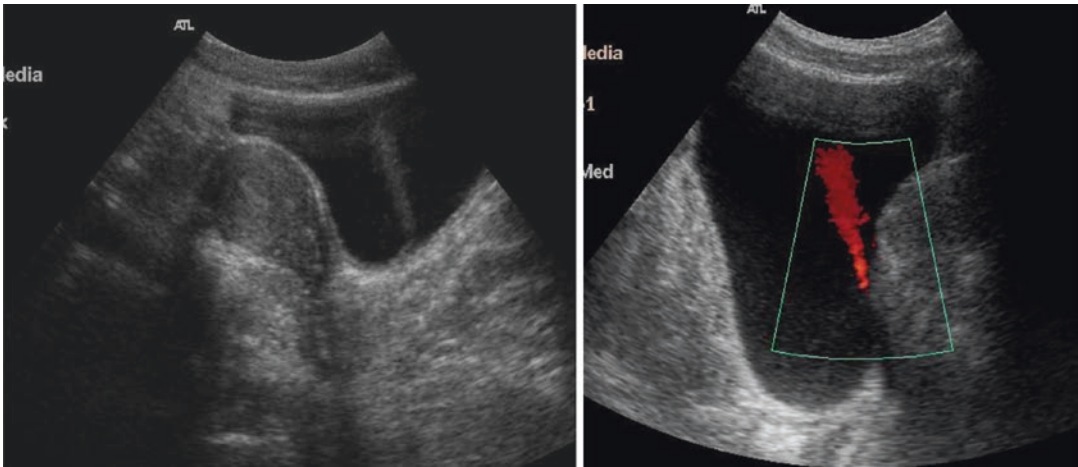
Normal ureteral jet. The arrival of urine into the bladder appears as a turbulence of the flow near the ureterovesical junction. Color Doppler confirms the presence of a high-velocity flow
